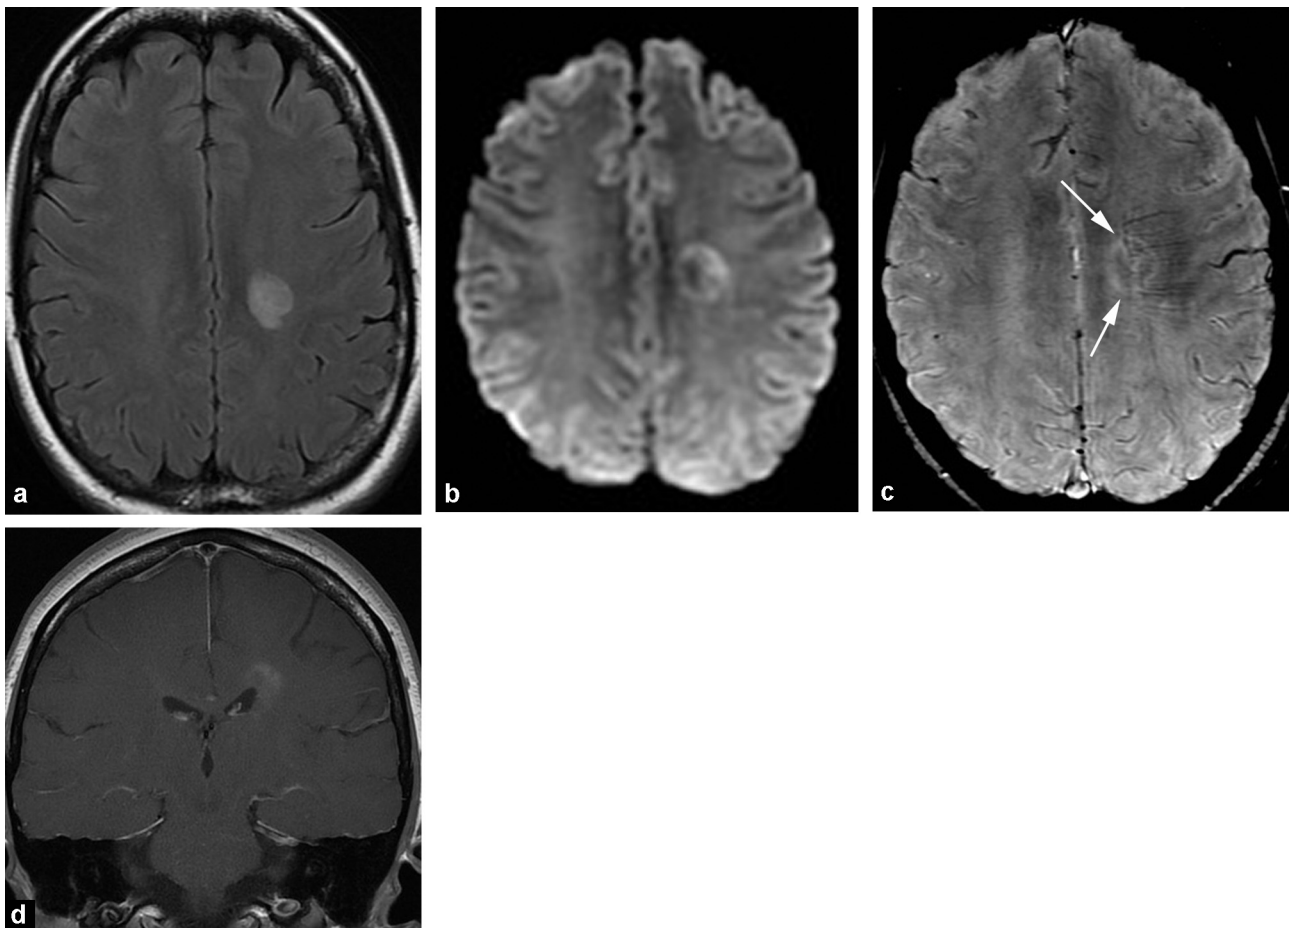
Multiple sclerosis. FLAIR axial (a), diffusion (b), SWI (c), T1 coronal after injection of gadolinium (d). A left juxtaventricular lesion in FLAIR hypersignal, with peripheral border in hypersignal in diffusion, without perilesional oedema, nor mass effect. In magnetic susceptibility imaging (SWI), the lesion appears as if it is being penetrated by multiple veins that appear dilated. After injection, the lesion is enhanced moderately and relatively homogeneously.
